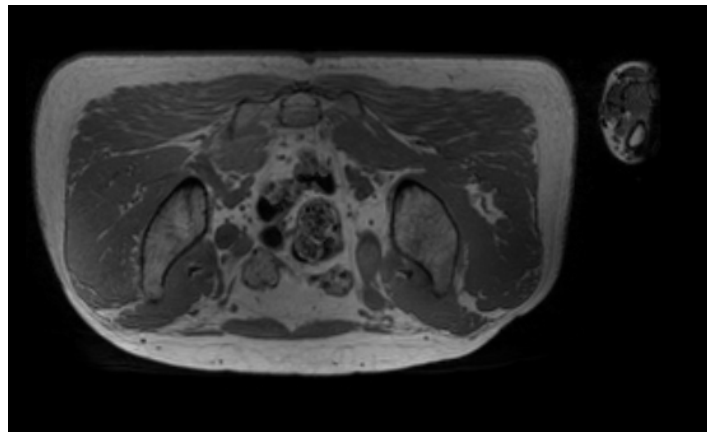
A slice of CT scan data in the transverse plane.
